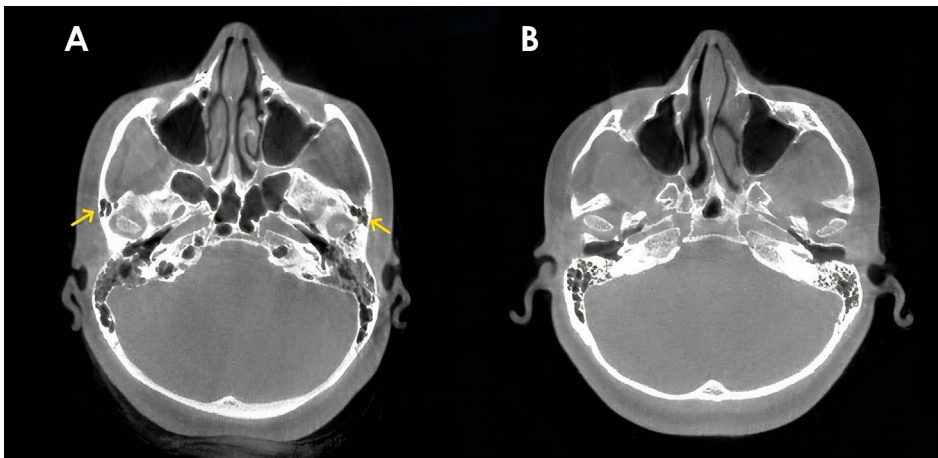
Axial cone-beam computed tomographic image of a patient with a pneumatized articular tubercle (A) and without a pneumatized articular tubercle (B).
